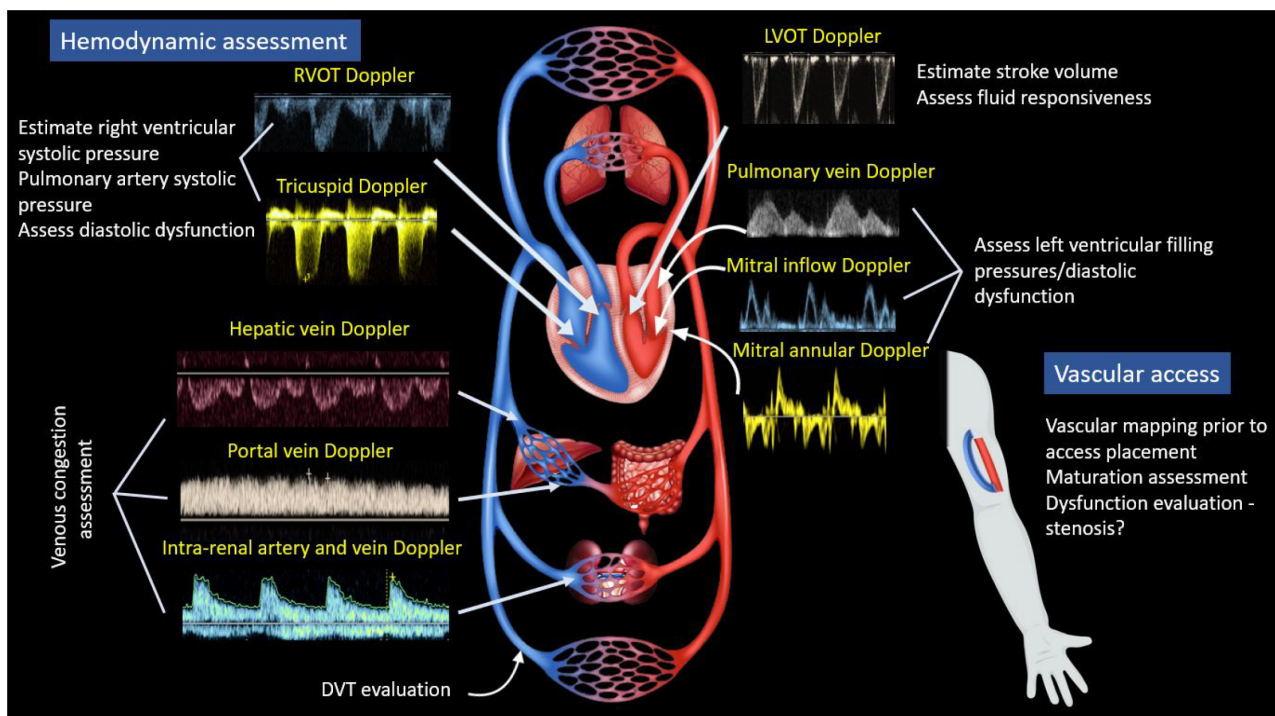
Advanced nephrology-related point-of-care ultrasonography applications involving spectral Doppler[2]. RVOT: Right ventricular outflow tract; LVOT: Left ventricular outflow tract; DVT: Deep vein thrombosis. Citation: Koratala A, Kazory A. An Introduction to Point-of-Care Ultrasound: Laennec to Lichtenstein. *Adv Chronic Kidney Dis* 2021; 28: 193-199. The authors have obtained the permission (Supplementary material).
